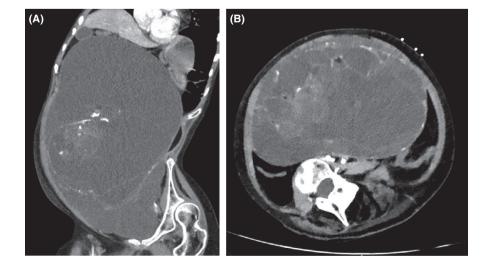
A, CT abdomen/pelvis, sagittal view. B, CT Abdomen/Pelvis, transverse view
